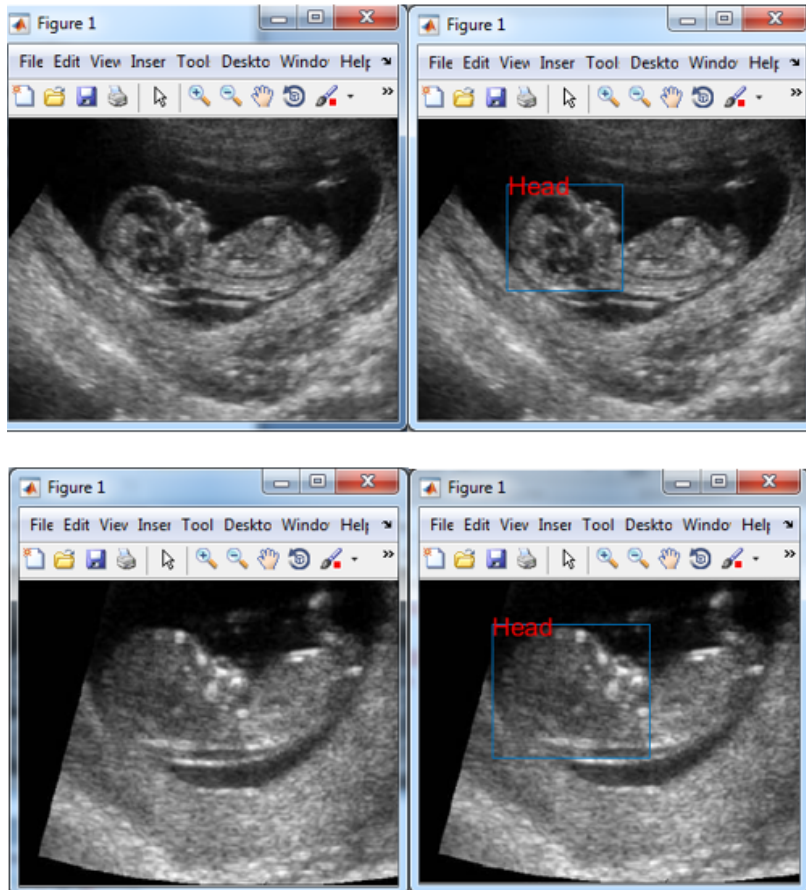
Input Ultrasound image and fetal Head detection
